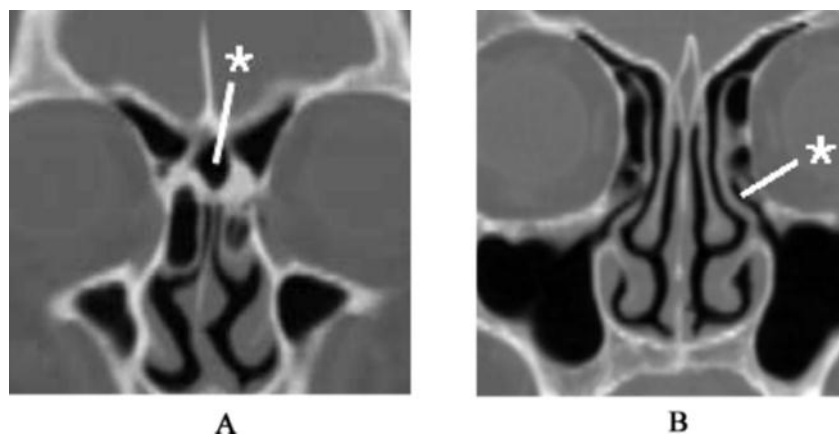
(A) IFSSC (*) is seen on coronal CT; (B) RT (*) is seen on coronal sinus CT.
